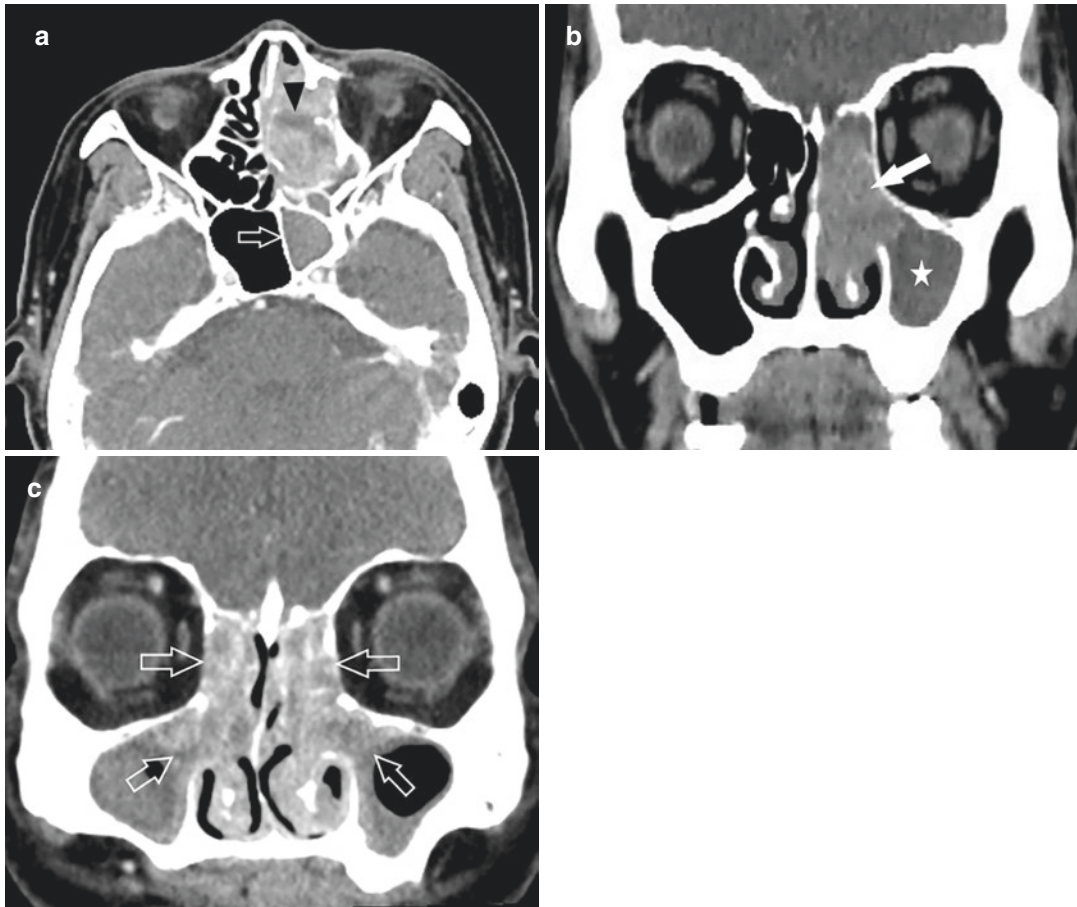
Malignancies of paranasal sinuses in three different patients. (a) Squamous cell carcinoma of the left ethmoid sinus. Axial contrast-enhanced CT image shows an inhomogeneously enhancing mass with ethmoid septa destruction. Note the necrotic area within the mass (black arrowhead). The left sphenoid sinus is opacified due to ostial obstruction (open arrow). (b) Diffuse large B cell lymphoma in the left nasal cavity, left ethmoid sinus and ostium of left maxillary sinus. Coronal contrast-enhanced CT image shows inhomogeneously enhancing soft tissue
